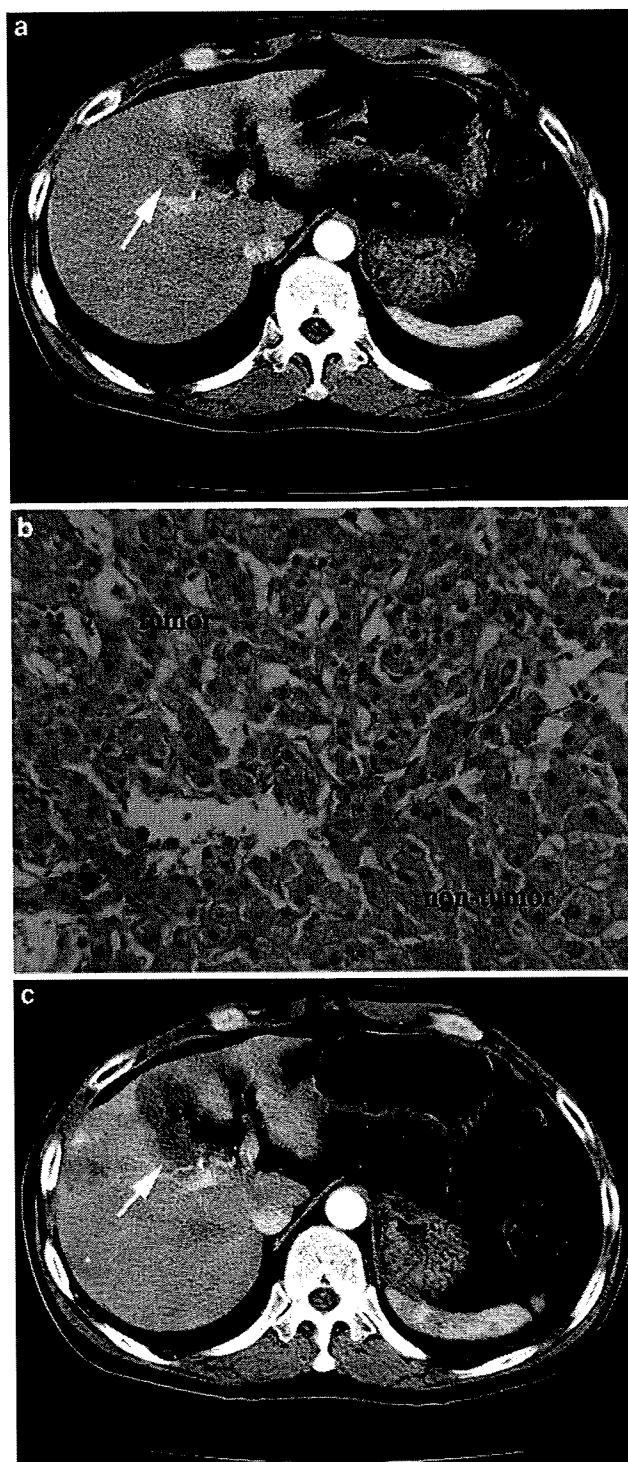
Before PEI: (a) contrast-enhanced CT revealed a ring-shaped enhancement in the early phase (*arrow*); (b) well-differentiated HCC was observed. After PEI: (c) contrast-enhanced CT revealed an LDA or no enhancement (*arrow*)
